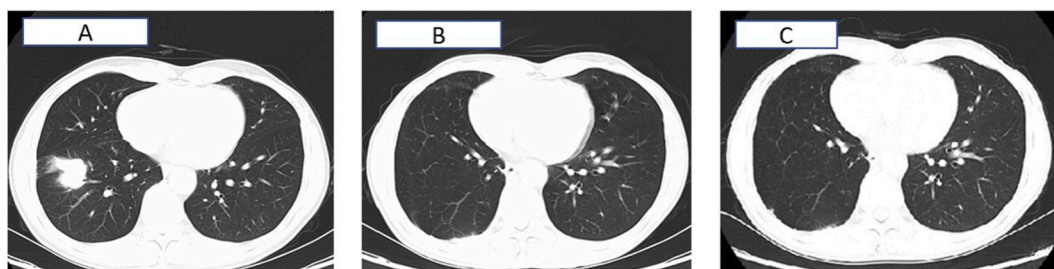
CT scan of the lung. (A) before surgery; (B) 2 month after surgery; (C) performed in April 2023, indicating the lung cancer was well-controlled.
